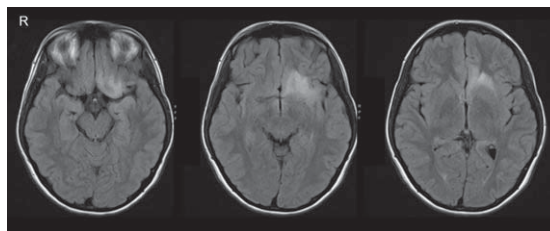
Non-enhancing T2/FLAIR (fluid-attenuated inversion recovery) hyperintensity on MRI approximately $3.9 \times 3.5 \times 2.0$ cm, centered in the left inferior frontal lobe. The lateral border of the lesion extends into the left insula. R, right.
